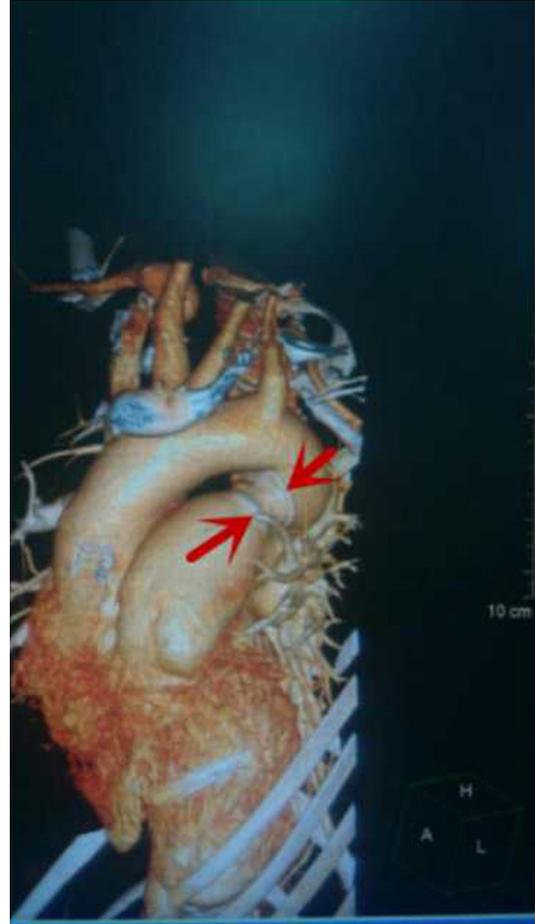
CT angiography showed the profile of the closure device (Red arrow).
